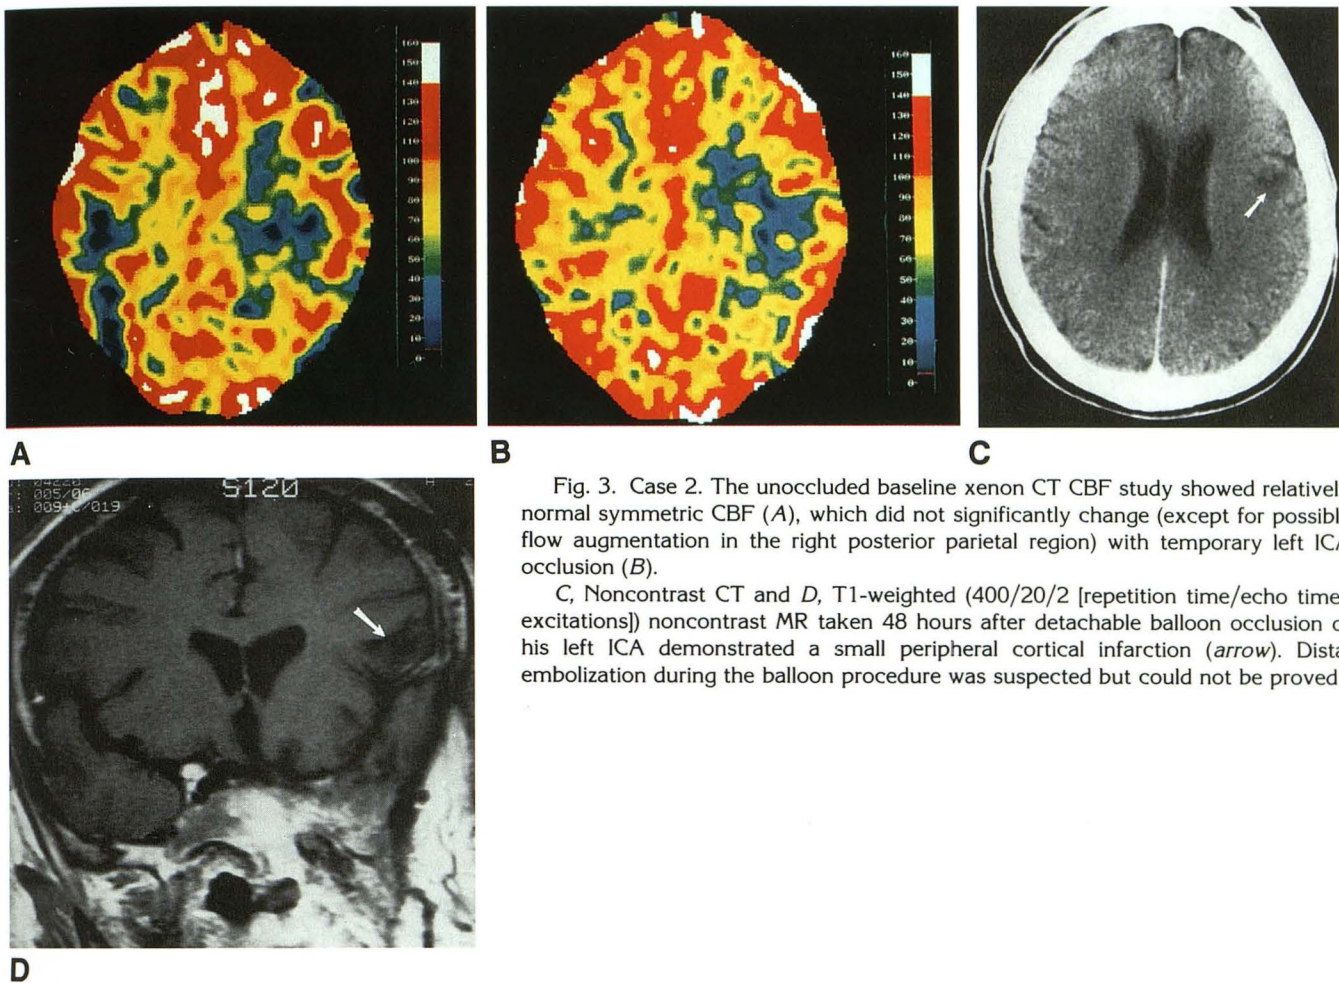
Case 2. The unoccluded baseline xenon CT CBF study showed relatively normal symmetric CBF (A), which did not significantly change (except for possible flow augmentation in the right posterior parietal region) with temporary left ICA occlusion (B).
